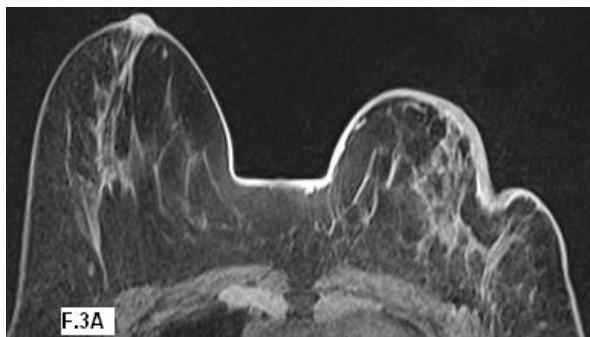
Scar tissue. 61 year-old female submitted to left quadrantectomy 1.5 years ago for ductal carcinoma. (A) Axial T1 GRE (VIBE) & (B) Axial S1TR demonstrate a left breast ill defined lesion at the surgical site. (C) DWI with b= 800 shows a hypointense ill defined lesion (arrow). (D) The ADC map shows hyperintense lesion (arrow) with ADC value of about $1.68 \times 10^{-3} \text{ mm}^2/\text{s}$. (E) Post-contrast study shows minimally enhancing lesion (arrow). (F) dynamic curve shows monophasic curve
